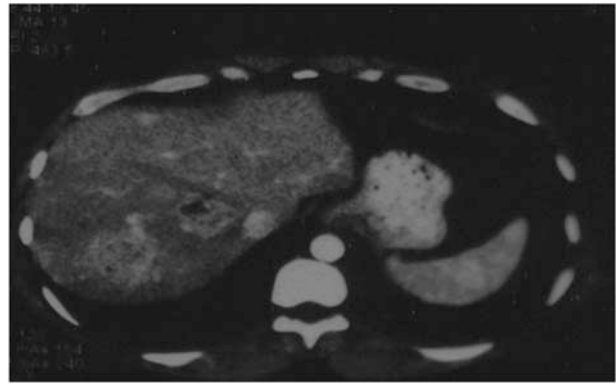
Computed tomography scan from December 2004 shows increase in size of the primary pancreatic lesion and increase in the number of the hepatic parenchymal lesions as compared to the June 20, 2003 scan (18-month interval).
